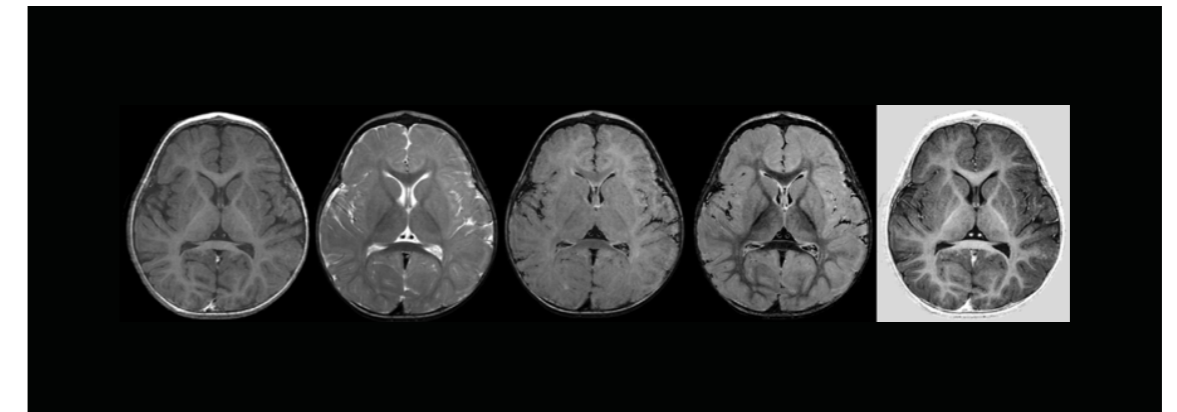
Fig. 8. Examples of SyMRI contrast images from a pediatric patient. From left to right: T1-weighted, T2-weighted, T2W FLAIR, DIR, PSIR.
